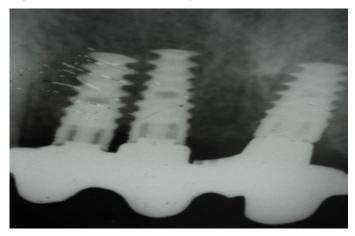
Periapical radiograph of framework implant interface
